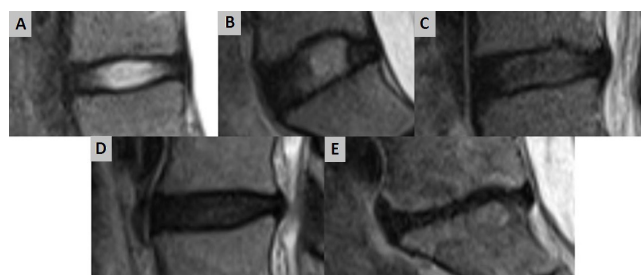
Grade I (A), grade II (B), grade III (C), grade IV (D), and grade V (E) intervertebral disc signal intensity on T2-weighted MRI, using the Pfirrmann classification.
